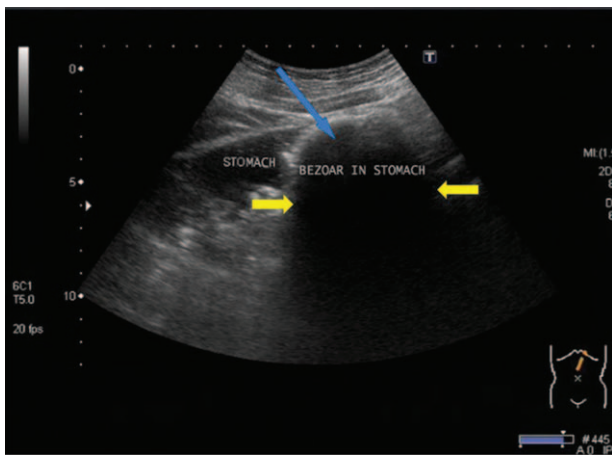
Gastric bezoar on ultrasonography. Gray-scale abdominal ultrasonography reveals an arc-shaped intraluminal mass (blue arrow) with a strong posterior acoustic shadow (yellow arrows).
